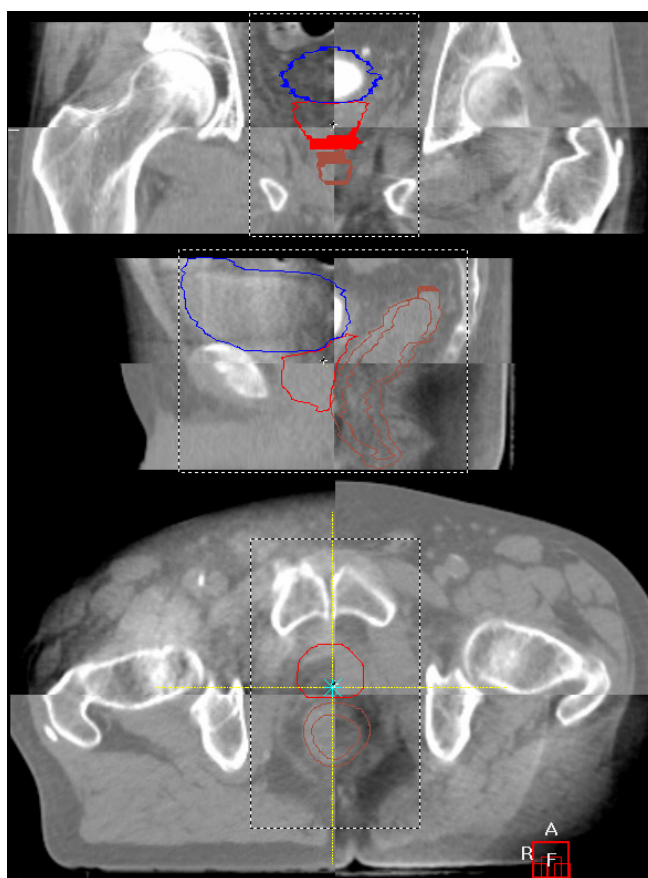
Match of planning CT and CBCT images for a clinical prostate case. Top: coronal view, centre: sagittal view, bottom: transverse view. Red line: PTV, blue line: bladder, inner brown line: rectum, outer brown line: expanded rectum, dashed line: user-defined region of interest for matching purposes.
